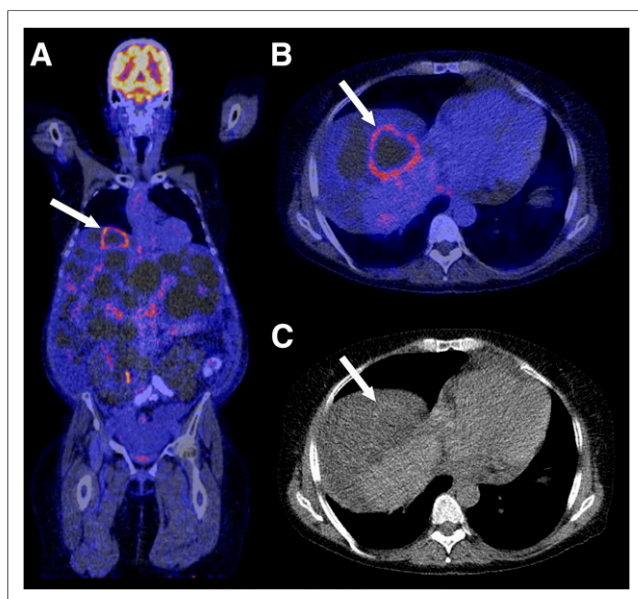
A 56-y-old woman who had ADPKD and whose ^{18}F -FDG PET/CT results were positive for hepatic cyst infection. (A and B) Coronal (A) and axial (B) fused ^{18}F -FDG PET/CT showed ^{18}F -FDG-avid cyst wall in liver segment 8 (arrows), indicative of infection. (C) Axial CT at same level showed cyst (arrow), but results were otherwise unremarkable. Criteria of Sallée et al. (5,10–13) for cyst infection were also met in this patient.
